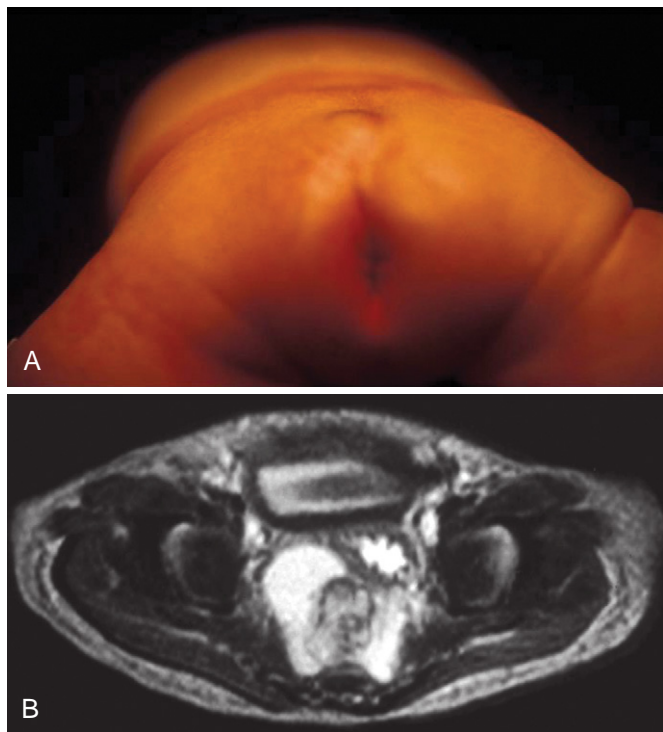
A, Three-month-old boy with a small external mass noted since birth. B, Underlying presacral mass noted on magnetic resonance imaging.
